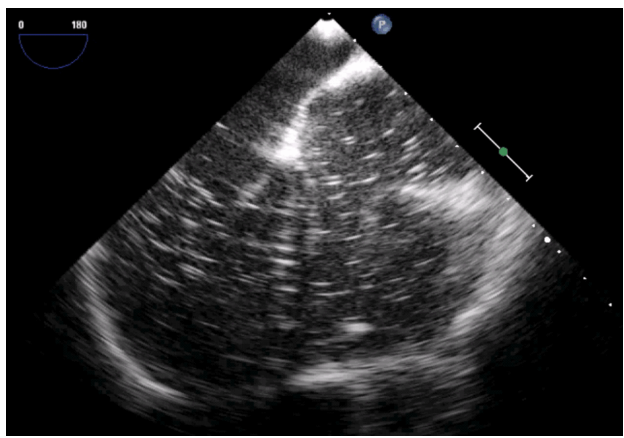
The same patient. Contrast transesophageal echocardiography showing opacification of both atria in the same time due to the presence of an innominate vein connecting the left superior vena cava to the right superior vena cava.
